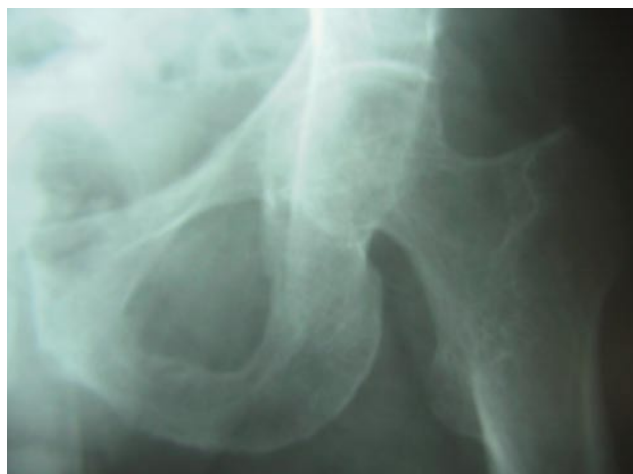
Case 2—Anteroposterior x-ray of left hip reveals osteopenia of femoral head and neck.
